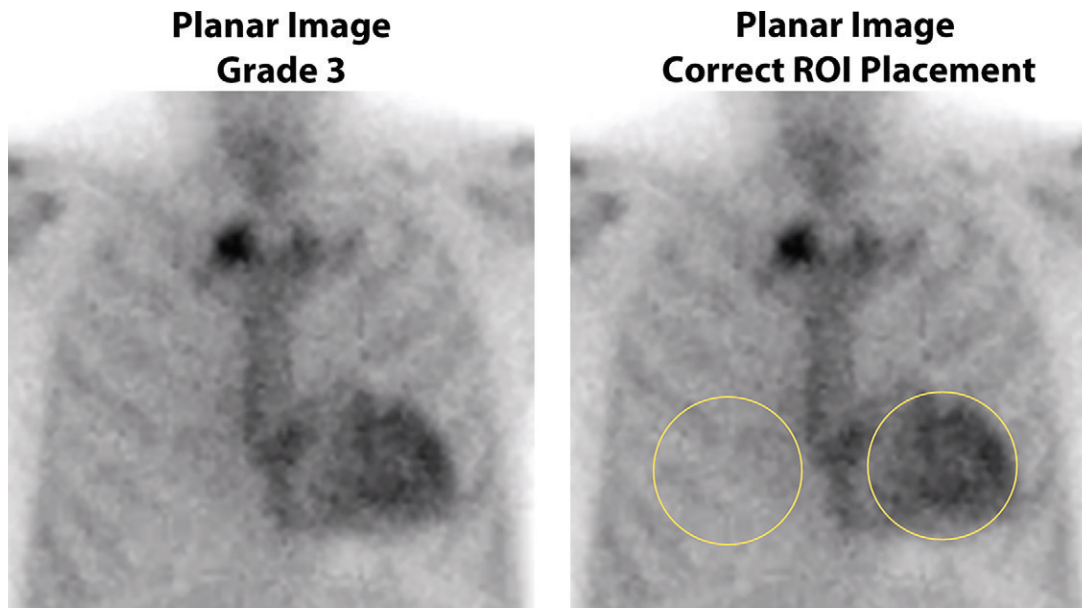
Semiquantitative method of heart-to-contralateral lung uptake ratio (H/CL ratio) uptake ratio on planar imaging at 1 hour after tracer injection. Anterior planar images acquired 1 hour after injection of technetium 99m pyrophosphate show grade 3 myocardial tracer uptake. Correct placement of regions of interest (ROIs) for the derivation of H/CL ratio is shown: The “heart” ROI should be drawn over the entire myocardium, and the “contralateral chest” ROI should be of the same size and mirrored over the contralateral chest on planar imaging at 1 hour. The ROI should be positioned to minimize overlap with sternal or focal rib uptake and maximize coverage of the heart without including adjacent lung. The H/CL ratio is optional and should only be reported if myocardial activity is noted on SPECT images.
